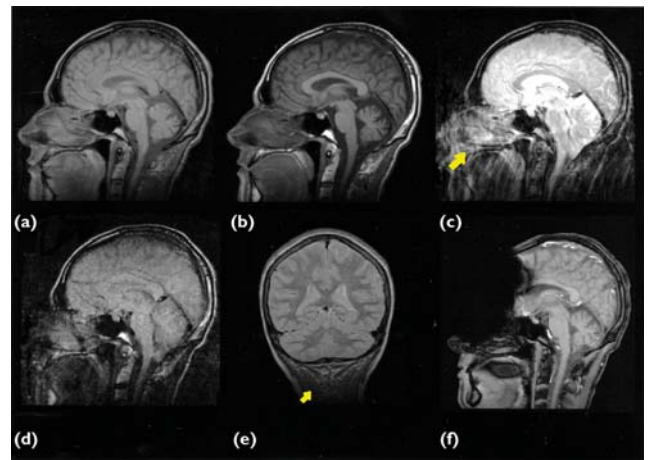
Spin echo MR images and artefacts. Top row, spin echo images: left, proton density image (TR = 2000 ms, TE = 20 ms); middle, T_1 -weighted image (TR = 350 ms, TE = 20 ms); right, T_2 -weighted image (TR = 2000 ms, TE = 90 ms). The arrow on the T_2 -weighted image indicates blurring caused by movement (swallowing) during acquisition. Bottom row, examples of poor tissue contrast and susceptibility artefact: left, spin echo image showing poor contrast due to injudicious prescription of pulse sequence (TR = 350 ms, TE = 90 ms); middle, bulk susceptibility artefact; right, ferromagnetic susceptibility artefact caused by a metallic hairclip.
